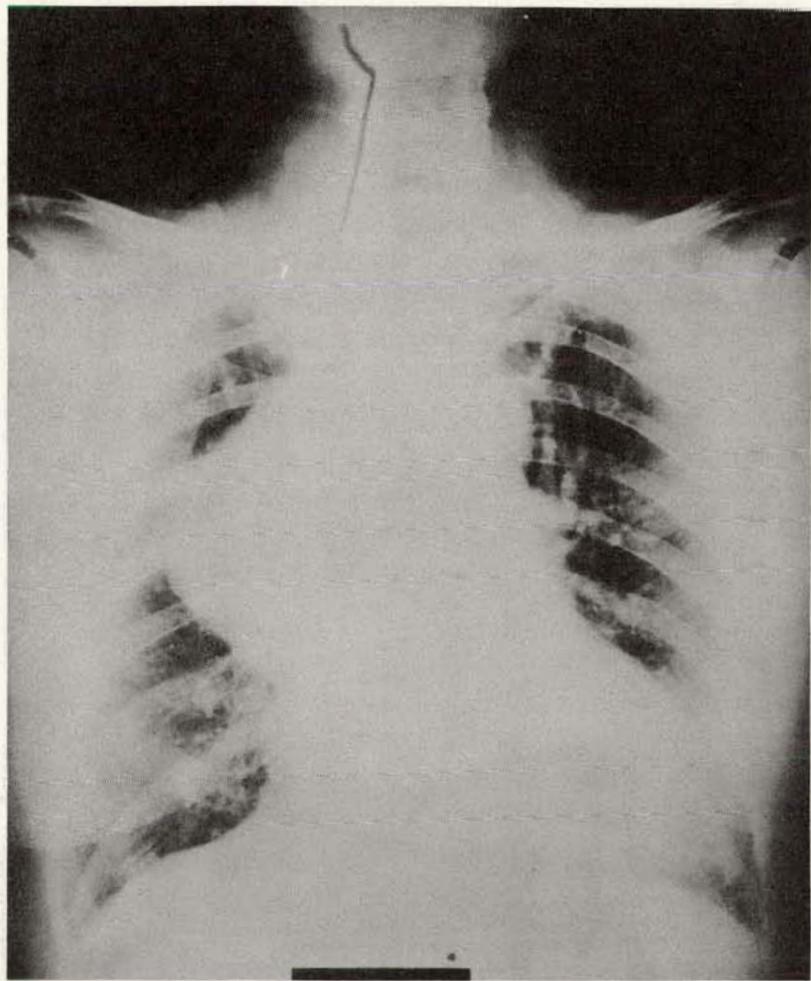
Roentgenogram of the chest of a 65-year-old woman. Clinical symptoms suggest thyrotoxicosis. Patient has no palpable thyroid. Her cardiac status was poor. Mediastinal shadow was tentatively interpreted as an aneurysm.
